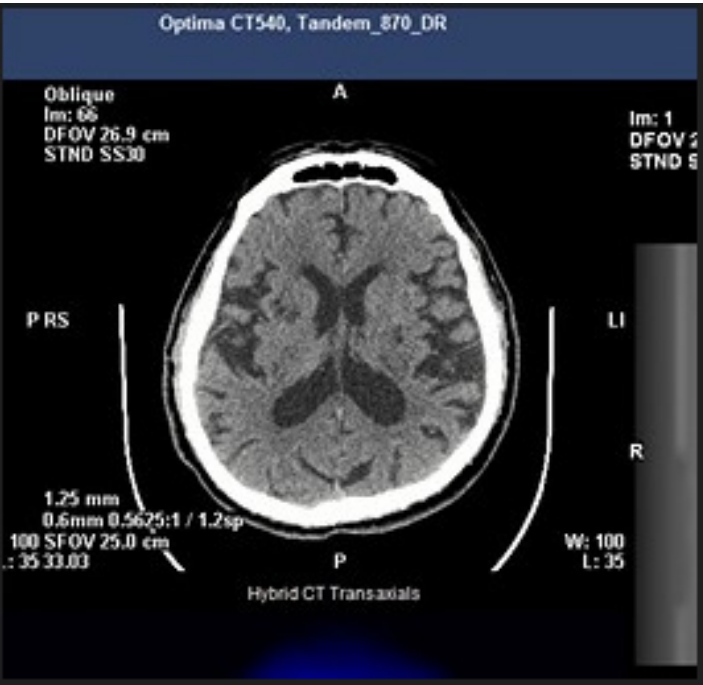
Brain computed tomography showed old lacunar infarcts in basal ganglia.
